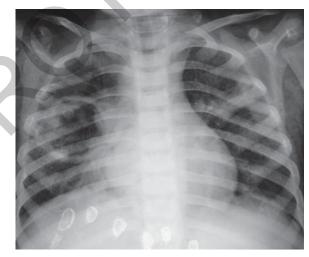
Chest X-ray showing a cavitary lesion.
